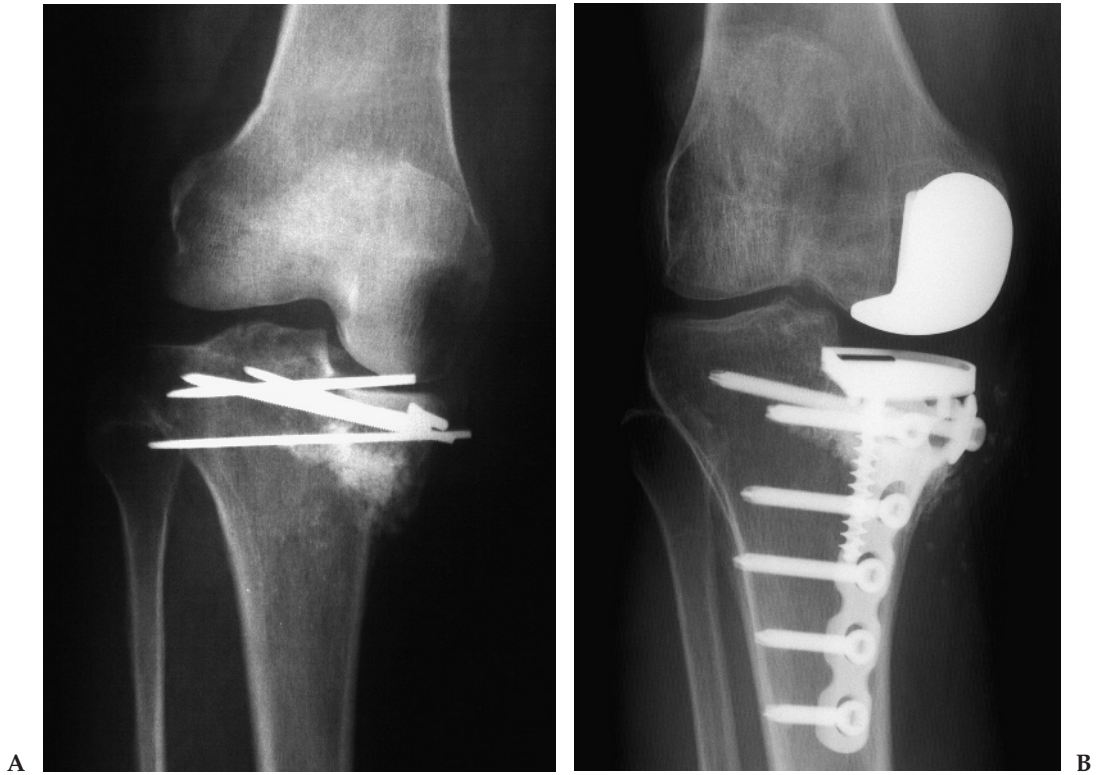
(A) Nonunion with varus nine months status post inadequate fixation of medial tibial plateau fracture in a 51-year-old woman. (B) Four year postoperative x-ray of uni reconstruction with soft-tissue release for a contracture using Sulzer Natural Knee Uni. Pre-op ROM, 5–65 degrees; post-operative, 3–122 degrees.
